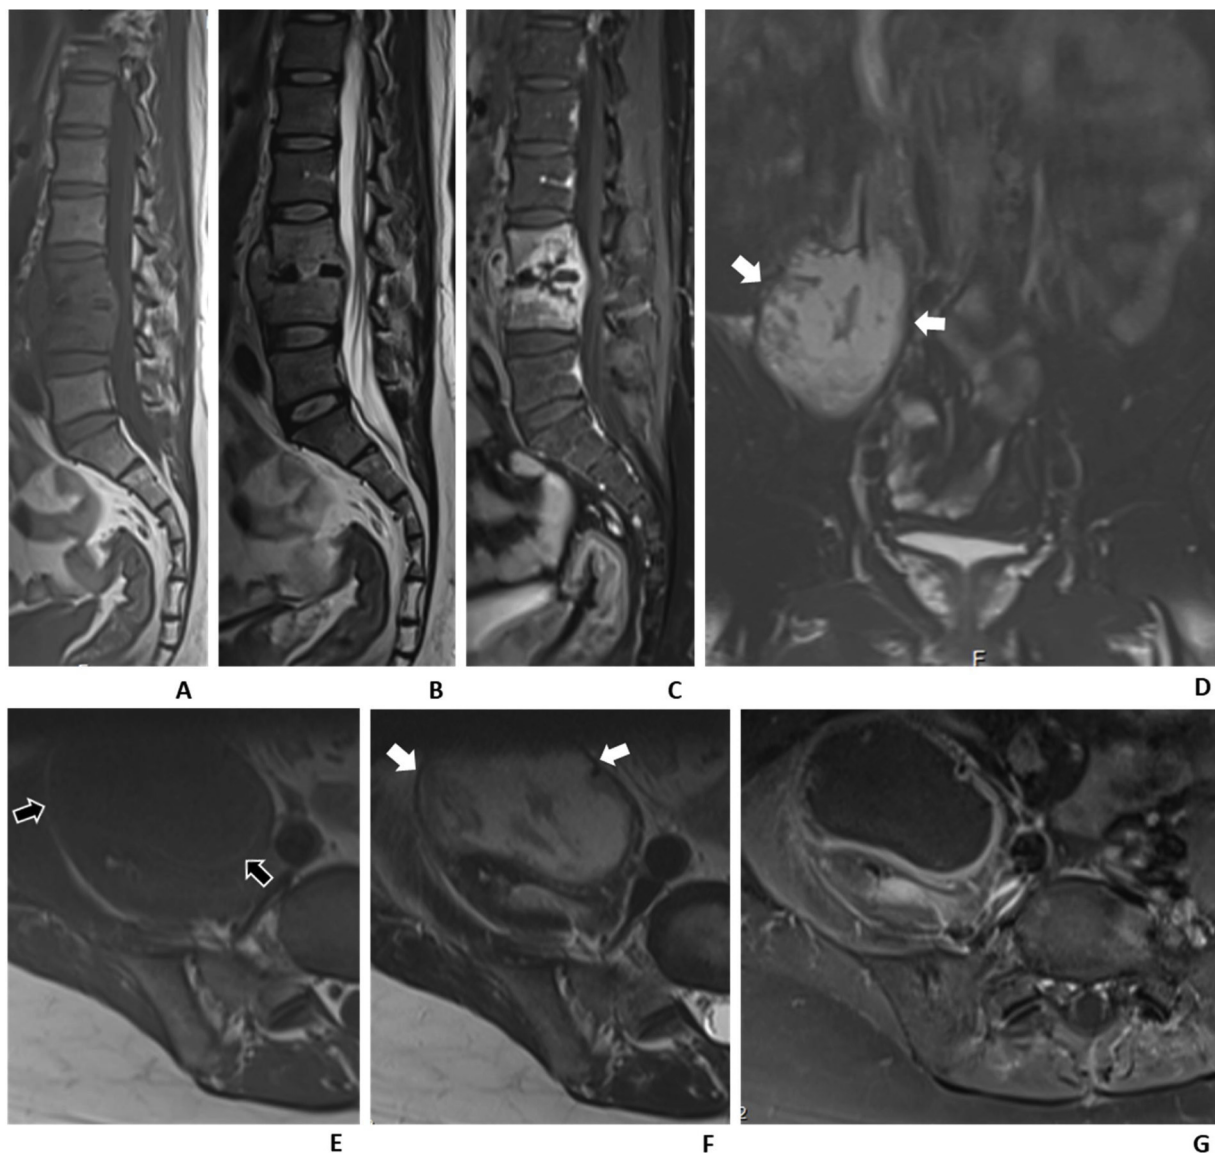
39-year-old man with L3/4 tuberculous spondylodiscitis and secondary pyomyositis at right psoas muscle. Sagittal T1-weighted, T2-weighted and contrast-enhanced T1-weighted fast spin echo (FSE) images (A)(B)(C) show L3/4 intervertebral disc and adjacent bony destruction. Coronal fat-suppressed T2-weighted FSE image (D) and axial T2-weighted FSE image (F) show right psoas muscle enlargement with intramuscular abscess and the abscess wall shows hypointensity (white arrows). Axial T1-weighted FSE image (E), the abscess wall appears hypointensity (black arrows) and on axial contrast-enhanced T1-weighted FSE image (G), the abscess wall appears smooth and thin.
